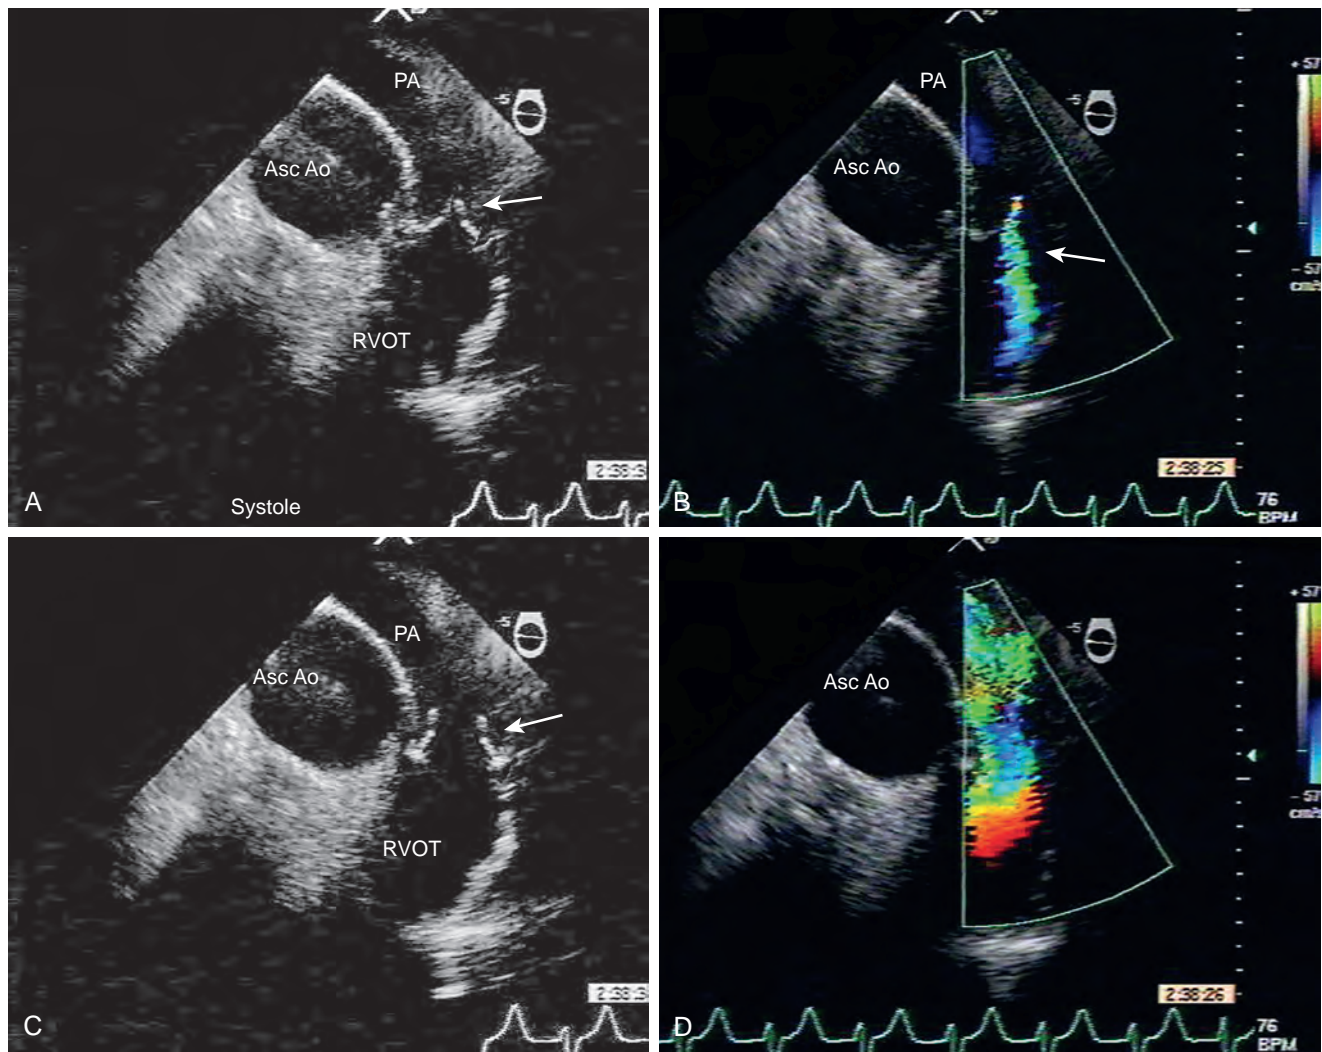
Pulmonary valve replacement: bioprosthetic valve. (A–D) Imaging from the upper esophageal windows of the main pulmonary artery (PA) and a cross-section of the ascending aorta (Asc Ao). Color Doppler imaging shows (B) the expected centrally directed regurgitant jet and (D) normal forward flows of a bioprosthetic valve. RVOT, right ventricular outflow tract.
